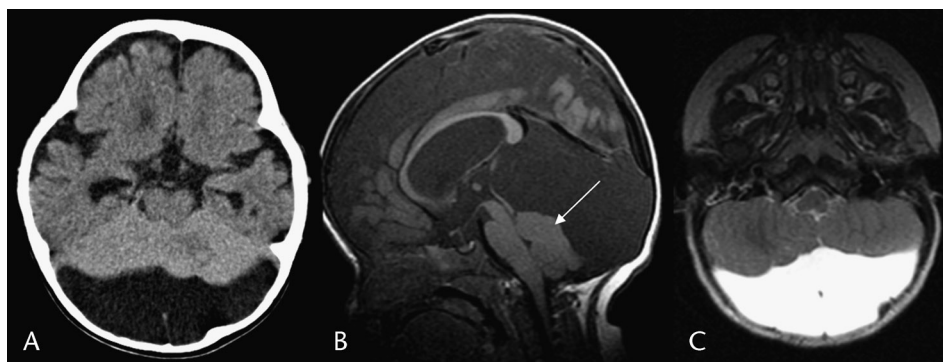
Retrocerebellar arachnoid cyst. Noncontrast CT (A) shows the low-density CSF collection behind the deformed cerebellum along with dilated temporal horns. Sagittal T1 (B) and axial T2 (C) images show a large cyst that expands the posterior fossa and compresses the formed vermis (white arrow) and cerebellar hemispheres. The fourth ventricle and aqueduct are open but compressed, resulting in HC.
